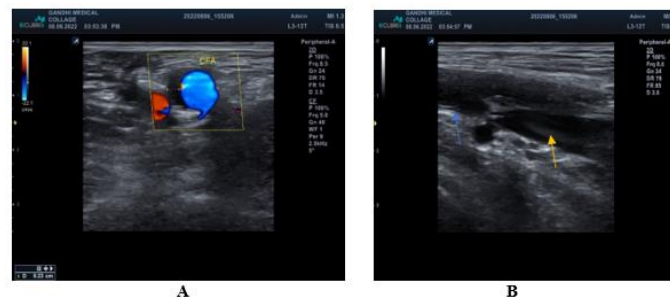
61 years old diabetic patient, came with left leg pain & distal toe gangrene (A) Color doppler study shows eccentric atherosclerotic wall thickening of maximum thickness measuring approx. 2.3mm left CFA causing 20% occlusion of its lumen, patent lumen shows normal color flow (B) Grey scale ultrasound image shows CFA (blue arrow) & its branches SFA & DFA with hyperechoic thrombus (yellow arrow) in DFA causing partial occlusion of its lumen.
